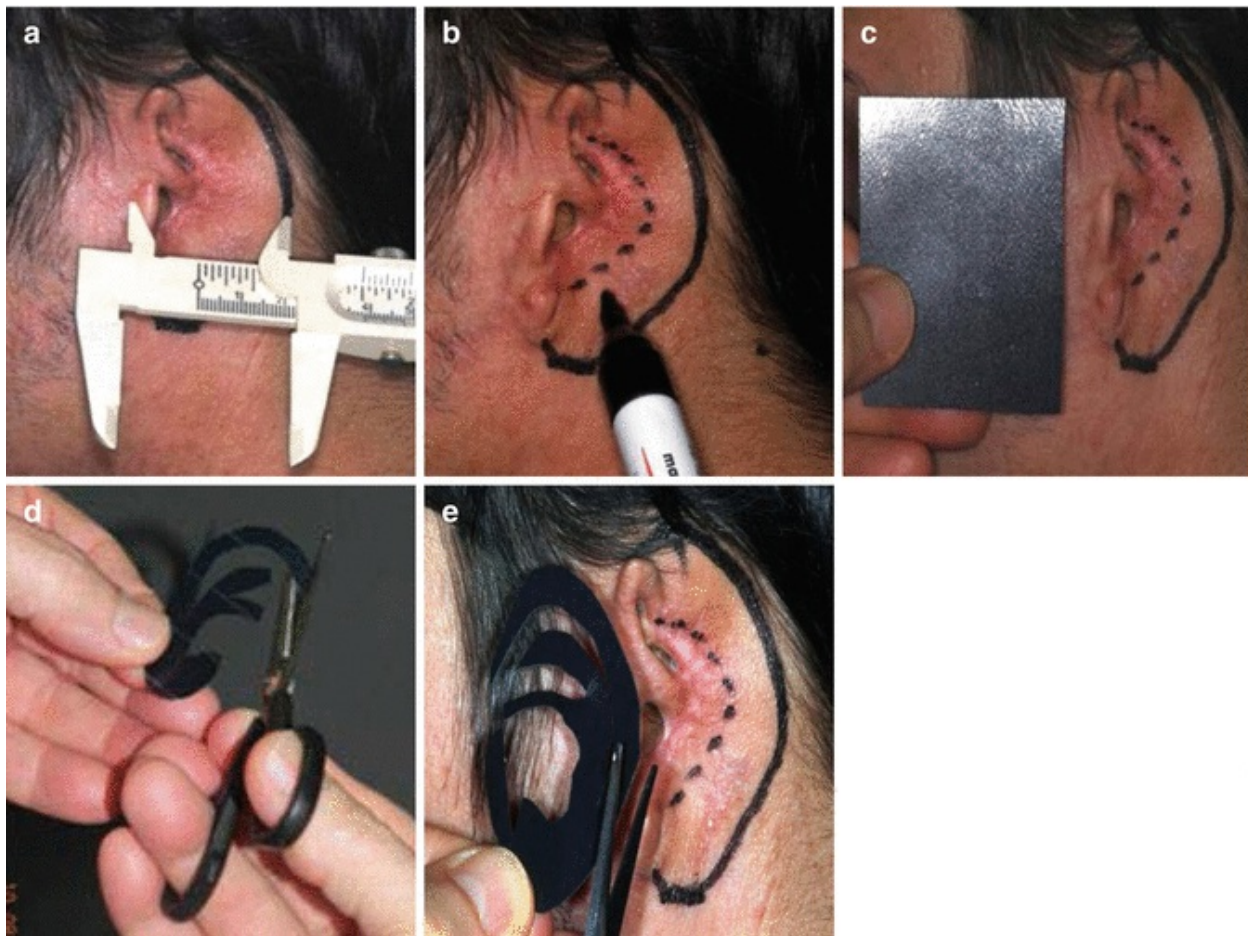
Importance of surgical planning and spatial projection before reconstruction of the ear detached by traumatic amputation. (a) by using a paquimeter, the size and shape of the future ear are established; (b) the location and position of the future auricle are marked, using the opposite ear as reference since it is normal; (c) The model of the future auricular skeleton is carefully created using X-ray film; (d, e) the model is then placed into the area of the projected auricle
